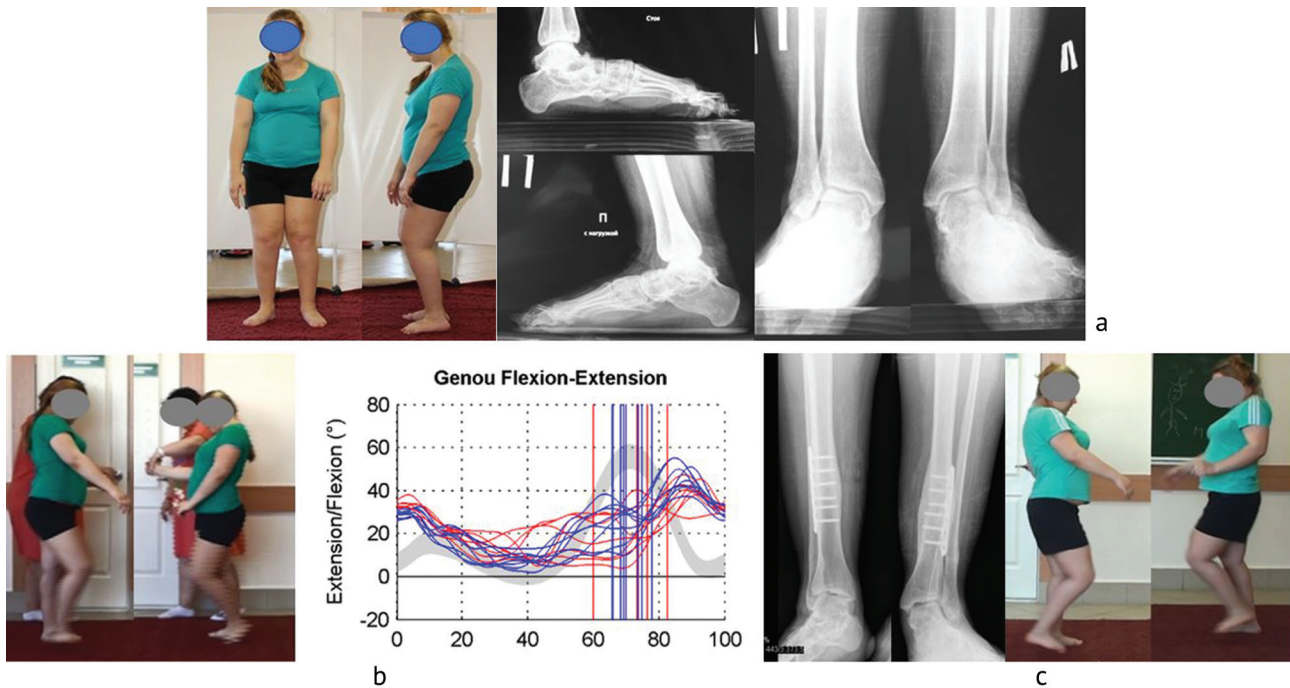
Patient, 16 years old, GMFCS level II, stiff knee gait, had previous bilateral triple arthrodesis of the feet: a – photo of the patient and radiographs of the feet show an excessive external rotation of the feet due to torsional deformity of the lower legs, flexion in the knee joints; b – photo of the patient and kinematogram that revealed that the maximum angle of flexion in the knee joint in the non-support phase varied between 38° and 45°, the onset of the flexion peak in the knee joint exceeded 80 % of the step cycle; c – patient underwent simultaneous bilateral detorsion osteotomy of the tibias, plate osteosynthesis as well as distal transfer of m. rectus femoris on the semitendinosus muscle and bringing the patellae down; 1.5 years after the operation, the patient is able to move independently; the maximum angle of flexion in the knee joint in the non-support phase of the step cycle varies between 60 and 68°
